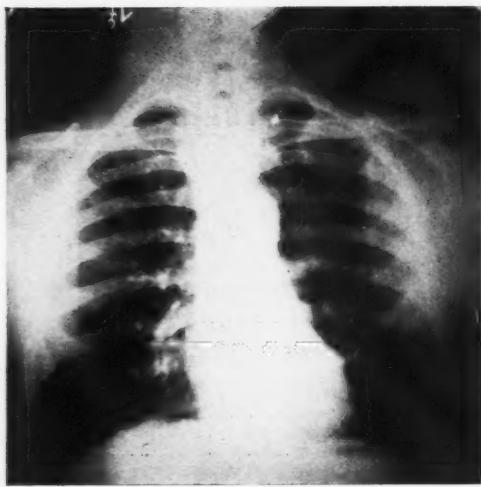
Case 1. X-ray negative 5 weeks prior to death; autopsy showed tumor around the left main bronchus.
